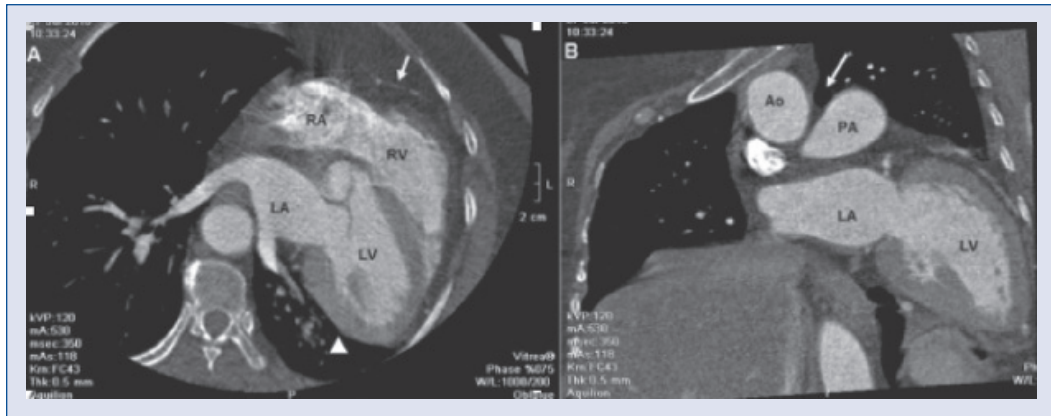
A. Cardiac computed tomography showing extreme levoposition of the heart, thin pericardium covering the right side of the heart (arrow) but absence of the left pericardium (arrowhead); B. Interposition of lung tissue between the aorta and main pulmonary artery (arrow) at the level of the aorto-pulmonary window; RA — right atrium; RV — right ventricle; LA — left atrium; LV — left ventricle; PA — pulmonary artery; Ao — aorta.
